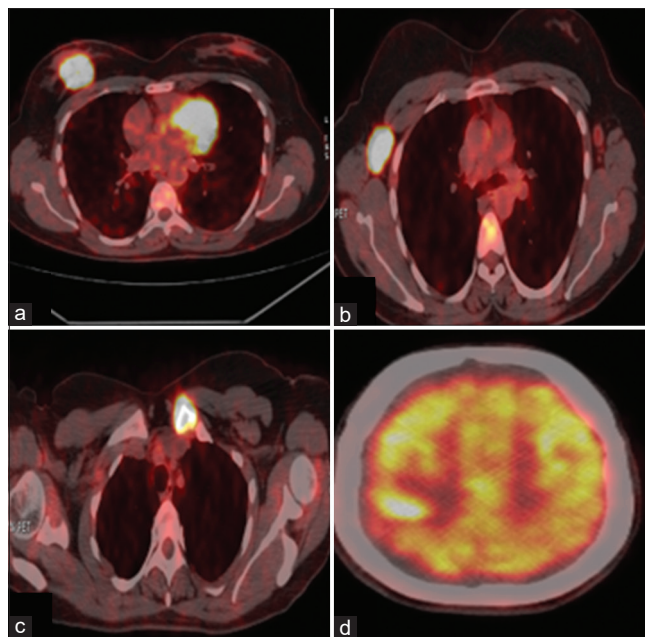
Positron emission tomography/computed tomography axial images showing: (a) hypermetabolic mass of the right breast, (b) hypermetabolic foci on a right axillary node, (c) hypermetabolic foci on the left clavicle, (d) right parietal cerebral hypermetabolic foci
